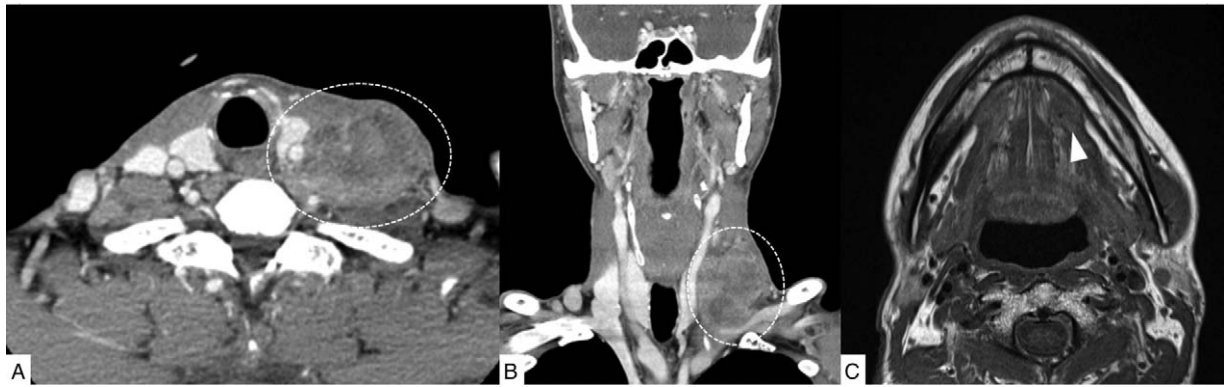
Enhanced CT scan with axial (A) and coronal (B) images shows the 5.7 × 3.8 × 5.7 cm sized, multi-lobulating mass with suspicious internal hemorrhage and peripheral heterogeneous enhancement (dotted circle and black arrow). (C) Axial magnetic resonance imaging findings of T1-weighted image show a 1.5-cm-sized ambiguous nodule in the left side of mouth floor (white arrow head).
